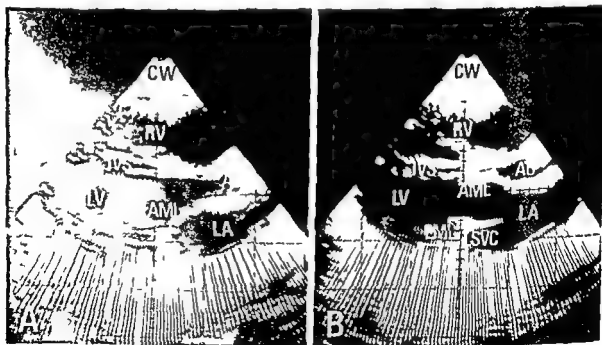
Cross sectional echocardiograms in the long cardiac axis in a 4 year old female patient having PLSVC with ASD and MI. Panel A is recorded in systole and panel B in diastole. The circular echo is presented posterior to the PML and it is larger in diastole than in systole. The echo discontinuity is recognized at the upper portion of the circular echo. Abbreviations: CW = chest wall, RV = right ventricle, IVS = interventricular septum, AO = aorta, LA = left atrium, LV = left ventricle, AML = anterior mitral leaflet, PML = posterior mitral leaflet, SVC = left superior vena cava.
